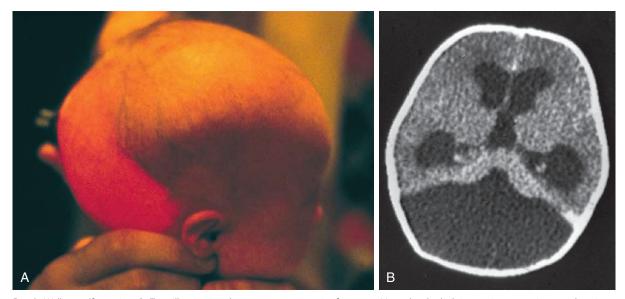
Dandy-Walker malformation. A, Transillumination demonstrates a posterior fossa cyst. Note also the bulging occiput, prominent scalp veins, and enlargement of the head. B, CT scan shows a posterior fossa cyst, a small cerebellar remnant, and associated hydrocephalus. (A, Courtesy Michael J. Painter, MD, Children's Hospital of Pittsburgh, Pittsburgh, Pa.)
